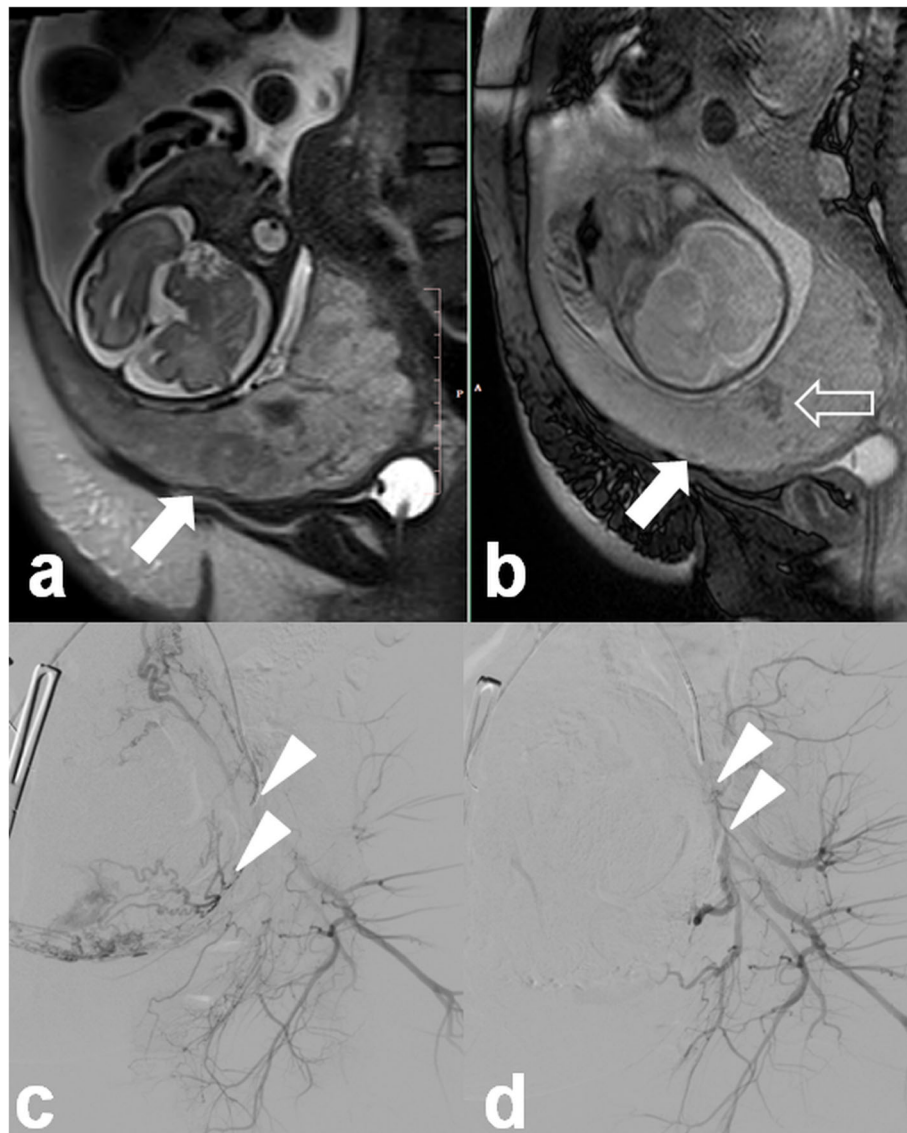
A 26-year-old woman (gravida –3) with history of previous Caesarean section. Sagittal T2 HASTE (a) and SSFP (b) MR images show placenta previa with loss of uteroplacental interface (arrows) and dark bands (open arrows). Since placenta accreta was present during elective Caesarean section, uterine artery embolization was performed. Digital subtraction images of left uterine artery pre-embolization (c) and post-embolization (d) (arrowheads)
